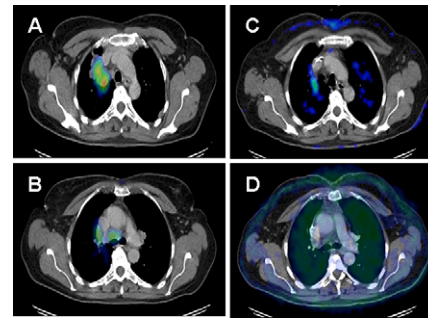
Right upper lobe large cell carcinoma (A) with right hilar and paratracheal adenopathy (B), both clearly FDG-avid on PET-CT fusion images. After induction chemotherapy, a major decrease in the metabolic activity of the primary tumour and absence of FDG-uptake in the mediastinum is noted. Patient underwent complete resection, pT1N0.
